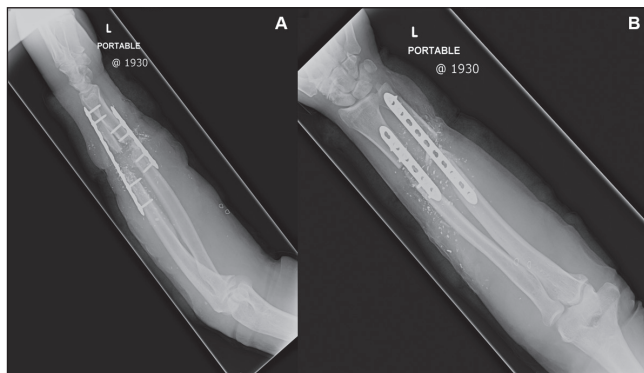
Preoperative x-ray images after return to home hospital. A Lateral x-ray image demonstrating adequate alignment achieved with plate and screw fixation. There is significant debris, bone fragments and soft tissue swelling. B Anterior-posterior x-ray image of the left forearm, demonstrating adequate alignment with plate and screw fixation of the distal radius and ulna. Also apparent are significant debris, bone fragments and soft tissue swelling
